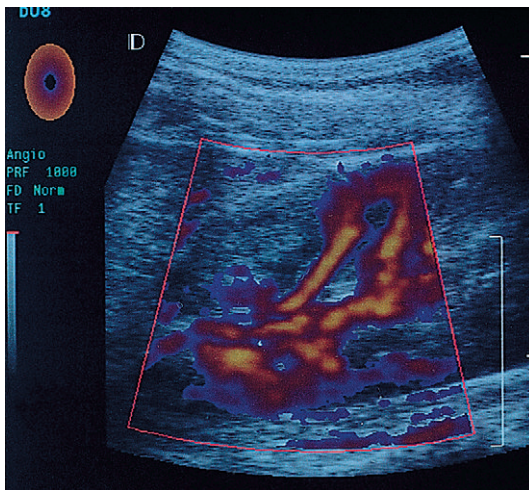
Colour power Doppler evaluation of a patient with focal ischaemia of the kidney. There is normal perfusion in the lower and mid-poles but the anterior surface of the upper pole is avascular.
